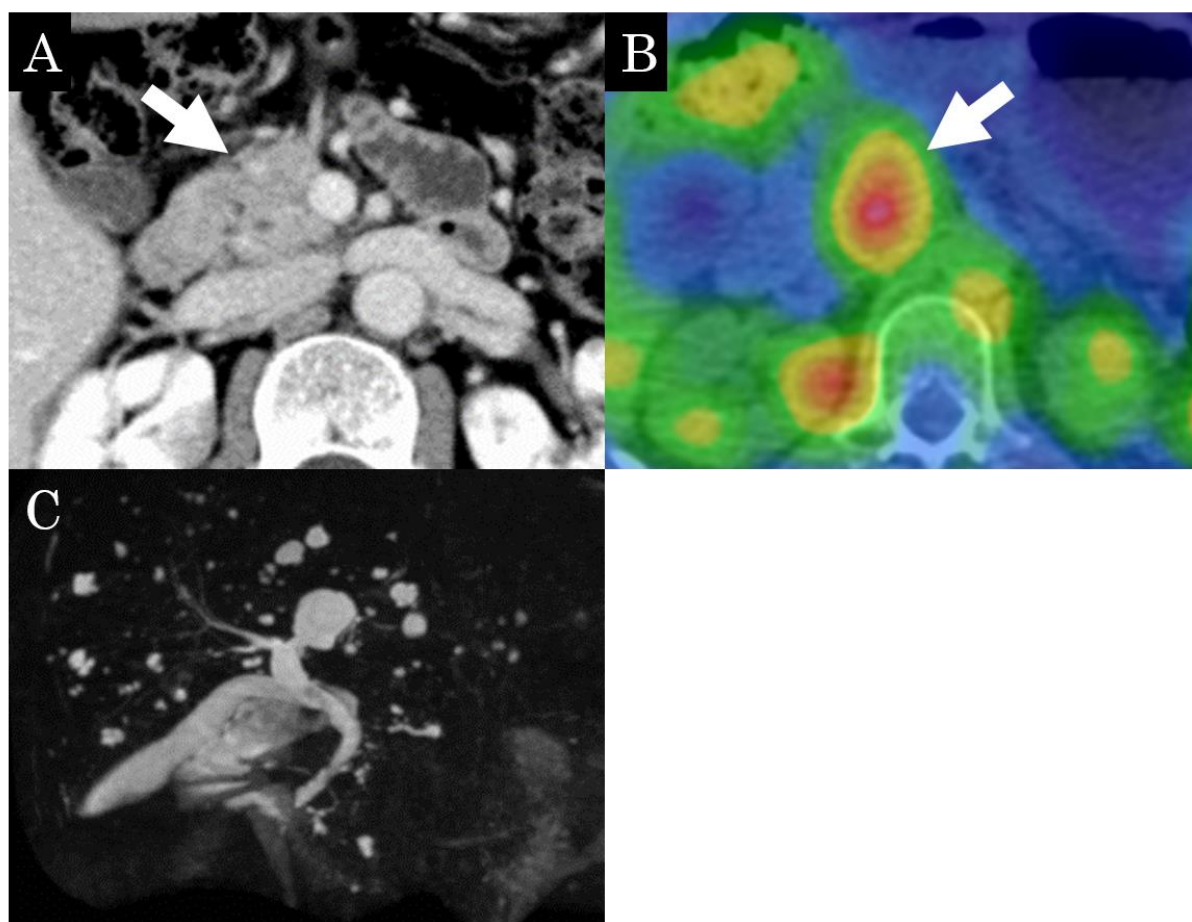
While contrast-enhanced CT does not indicate pancreatic enlargement (A, arrow), a ^{67}Ga SPECT/CT shows accumulation in the remnant pancreas after resection (B, arrow). Magnetic resonance cholangiopancreatography does not indicate a stricture of the main pancreatic or bile ducts (C).
